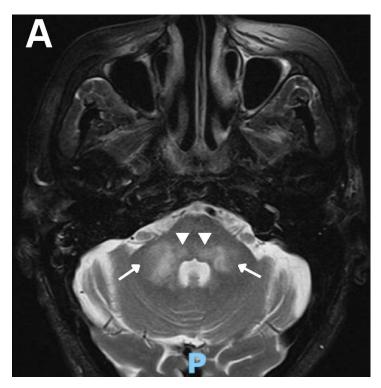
T2-weighted axial MRI of the brain demonstrating white matter hyperintensities involving the dorsal pons (arrowhead) at the level of the facial colliculus and bilateral middle cerebellar peduncles (arrows)
